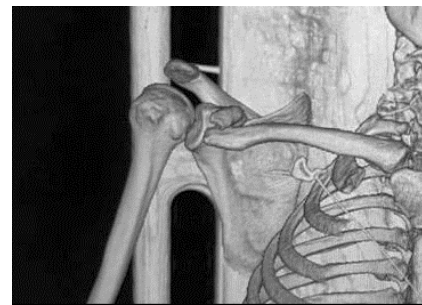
3D reconstruction of total body CT scan executed on patient arrival at emergency department. Detail of right shoulder.
